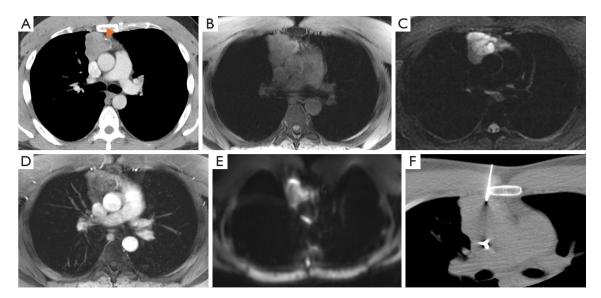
Thymoma imaging with different radiographic modalities. (A) Axial chest computed tomography shows a smoothly marginated, heterogeneously enhancing soft tissue mass in the anterior mediastinum with a punctate calcification (orange arrowhead). Magnetic resonance imaging signal characteristics of the mass demonstrate (B) T1 iso-intensity on axial T1-weighted images, (C) heterogeneous T2 hyperintensity on T2-weighted images, (D) heterogeneous enhancement on axial T1 post-contrast images, and (E) restricted diffusion on diffusion-weighted imaging. (F) Computed tomography-guided biopsy resulted thymoma.
